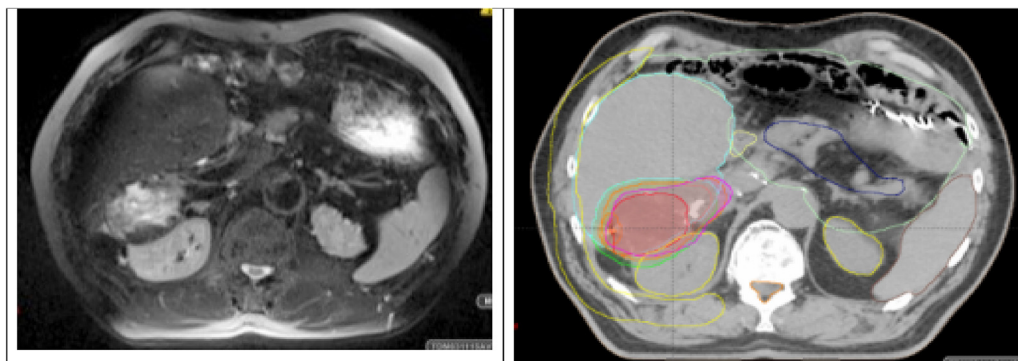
MRI with registration based on fiducial markers.
